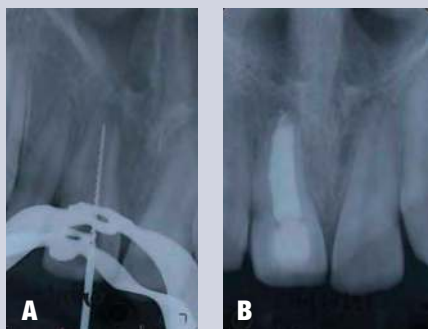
(A) Preoperative radiographic of tooth #8 prior to multi-appointment calcium hydroxide treatment to induce apexification. (B) One-year follow-up. While the tooth is asymptomatic and functional, thin root walls put the root at increased risk of fracture.
